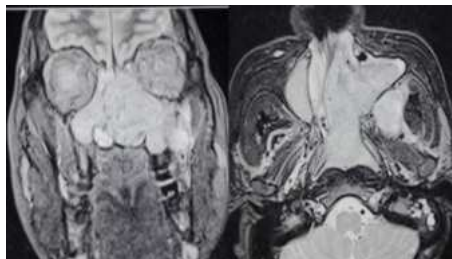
MRI PNS with Brain in coronal and axial views
